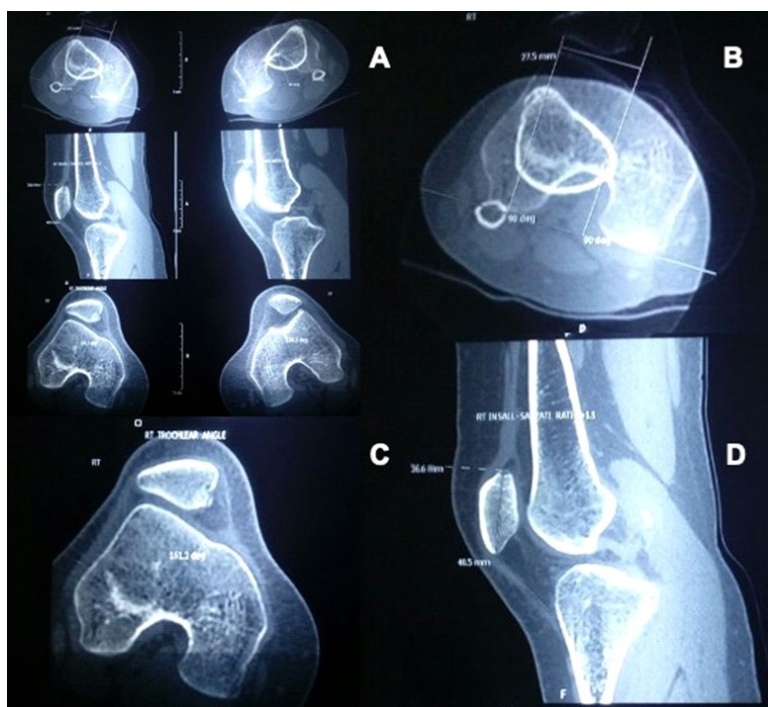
A: CT Scans of both knees. B-D: CT of Right knee with measurements. B: TTTG distance 22.5mm, C: Trochlear Angle 161 degrees, D: Insall - Salvati Ratio 1.1
